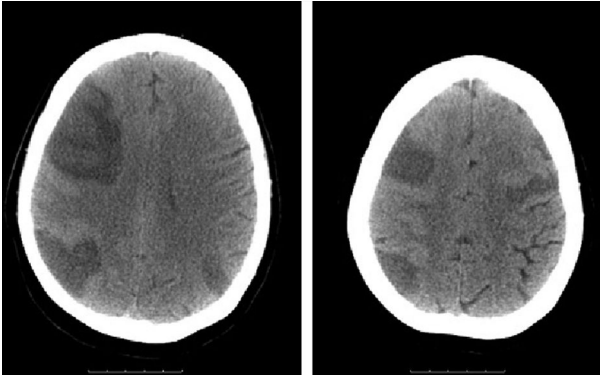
Two slices of a CT brain scan in a patient who suffered cardiac arrest. The hypodense areas are regions of infarction. They are visible in the anterior and posterior border zones. © Hugh Markus.
